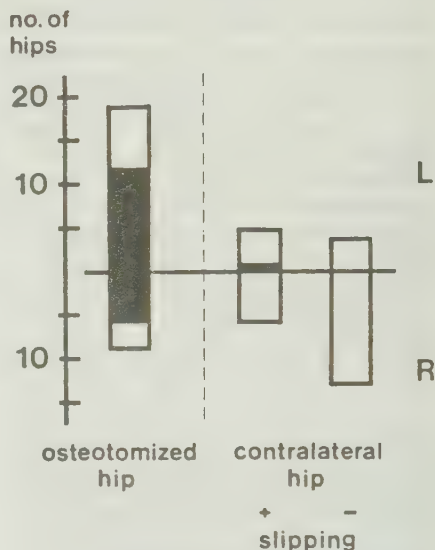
Slipping and arthrosis at radiographic follow-up evaluation in 28 patients. ■ = arthrosis; □ = no arthrosis.
